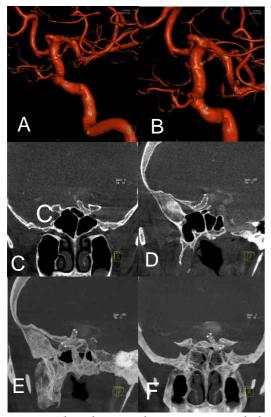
Three-dimensional reconstruction, in which is appreciated complete absence of the aneurysm, with appropriate visualization of the proximal and distal stent markers (A and B). – Dynamic CT angiography coronal and sagittal sections, where appropriate stent patency and showing minimal filling of the aneurysm (C, D, E and F)
